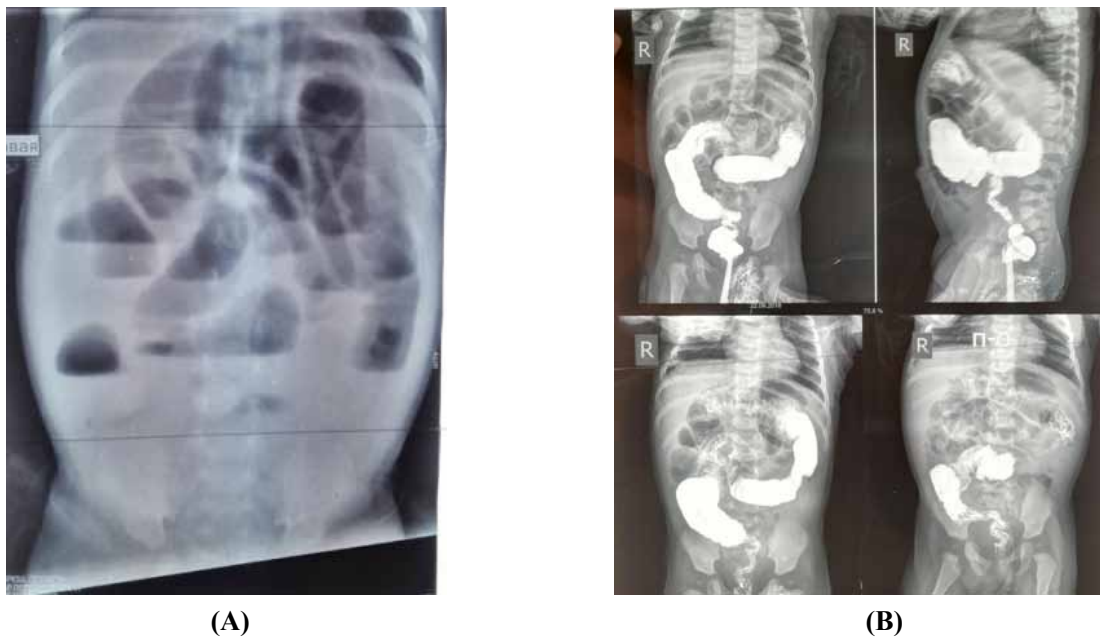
A - plan radiography of the abdominal cavity; B - Irrigography
